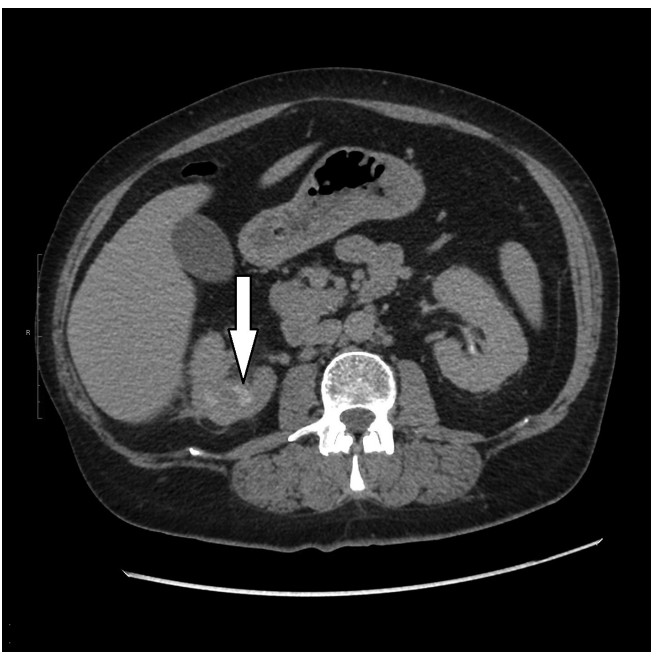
CT scan revealing one of the hypodense lesions in the right kidney
